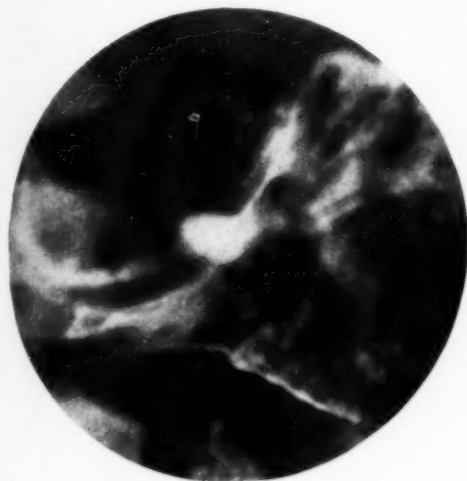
Spot roentgenogram of the prepyloric region. The large fleck of barium represents the ulcer niche as it appeared on Aug. 7, 1948.
